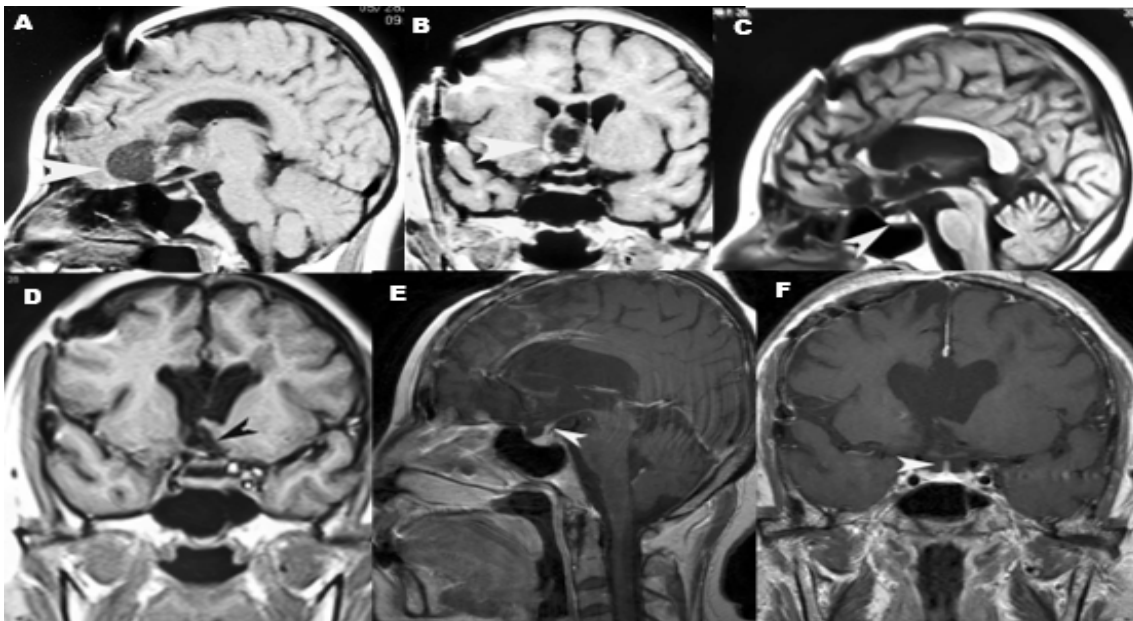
Second preoperative sagittal (A) and coronal (B) MR images revealed a mixed cystic and solid tumor in the anterior third ventricle and suprasellar region, with the arrowhead pointing to the tumor. Second postoperative sagittal (C) and coronal (D) MR images showed no residual tumor within the third ventricular structure, with the arrowhead pointing to the pituitary gland and the third ventricular floor. At the 25-year follow-up, sagittal (E) and coronal (F) enhanced MR images showed no evidence of tumor growth and preserved hypothalamic structure. The arrowhead indicates the pituitary stalk.
